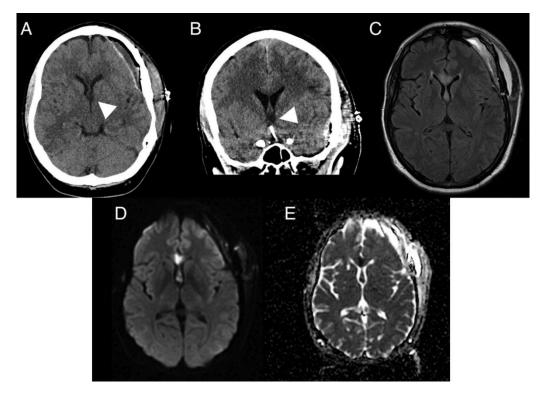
Axial (A) and coronal (B) CT demonstrating low density in the genu of the corpus callosum, fornix and subcallosal region indicative of an ischemic injury. Axial FLAIR (C), diffusion-weighted imaging (D), and apparent diffusion coefficient maps (E) demonstrating forniceal and genu of corpus callosum infarction.
